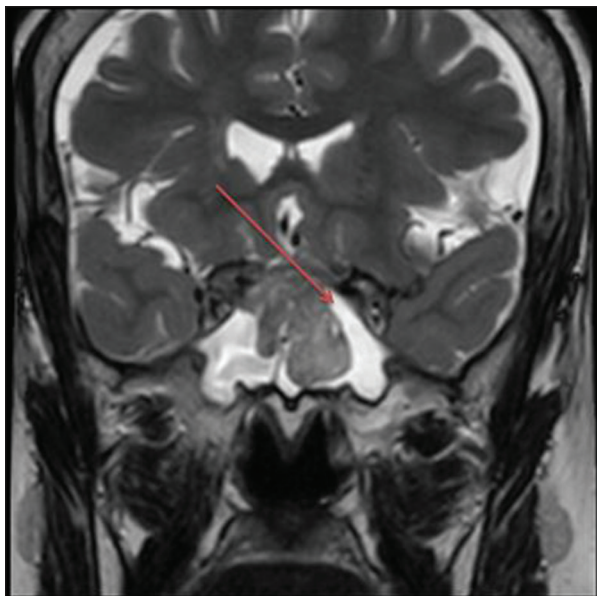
Coronal T2-weighted magnetic resonance image of the brain at the level of the sphenoid sinus with pituitary protocol shows T2 hyperintense fluid in the sphenoid sinus with similar intensity as cerebrospinal fluid (CSF) (arrow) worrisome of CSF leak through defect in sellar floor
